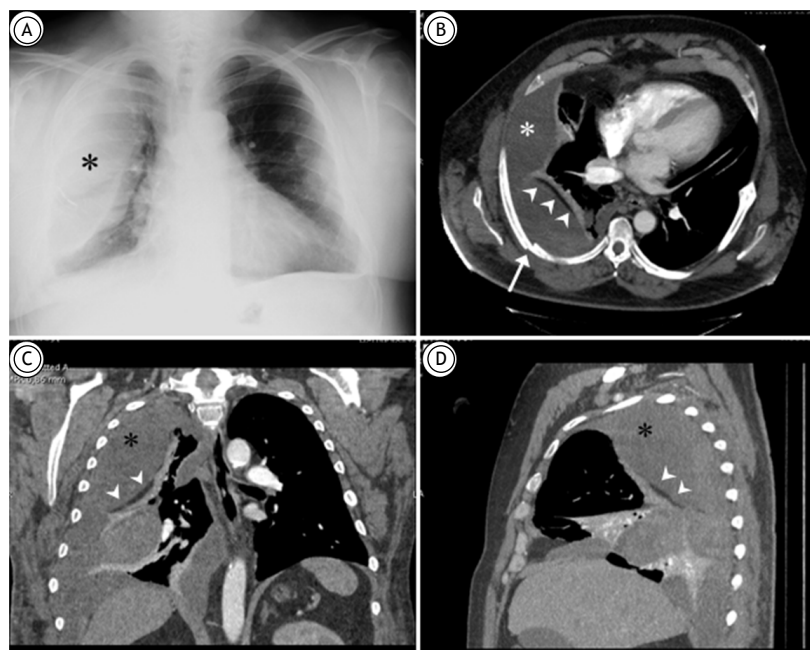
(A) Posteroanterior chest X-ray showing right rib fractures and a large extrapulmonary opacity (asterisk). Axial (B), coronal (C), and sagittal (D) reconstructions of chest CT scan (mediastinal window) reveal rib fractures (arrow) and a large extrapulmonary collection (asterisks) separated from the atelectatic lung parenchyma by a linear fat-density image (arrowheads) corresponding to the extrapleural fat sign, consistent with an extrapleural hematoma.
